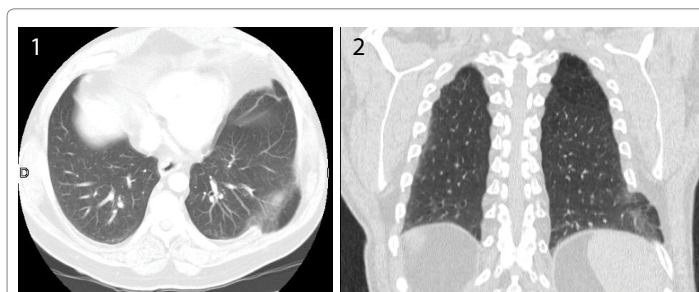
CT: pulmonary hernia.
